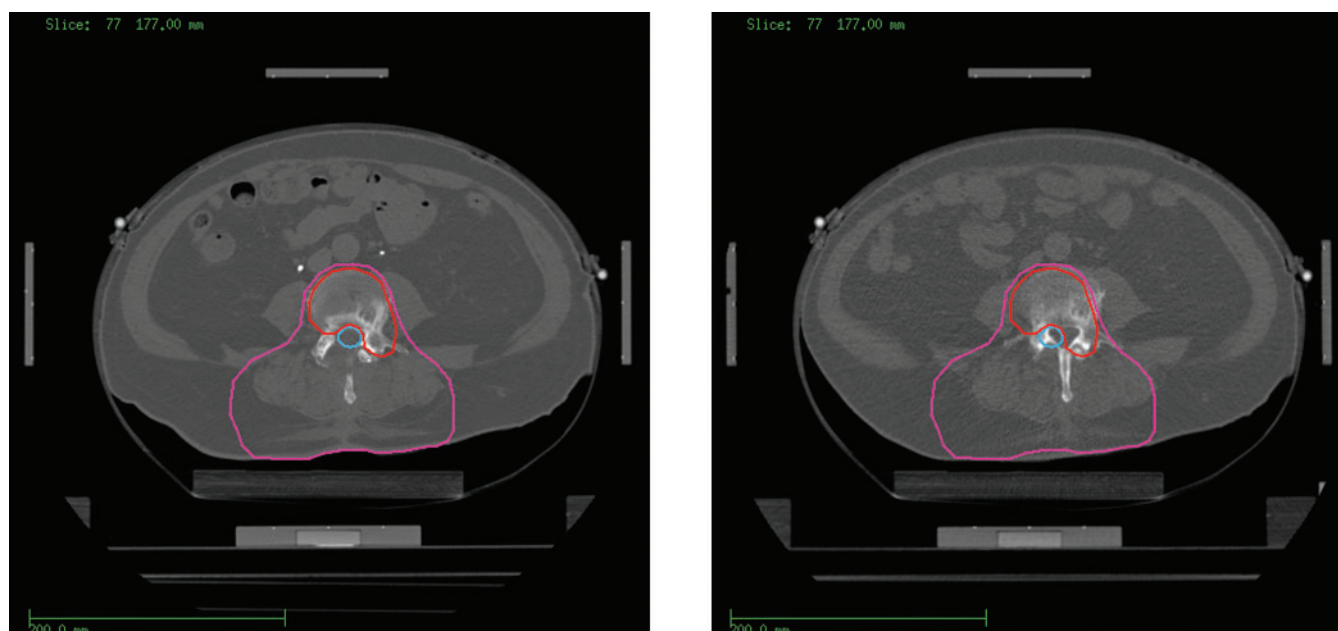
Planning CT scan and control CT scan at fraction 20 of the paraspinal case #7. The contours of the target volume, the boost volume and the spinal cord are also shown.
